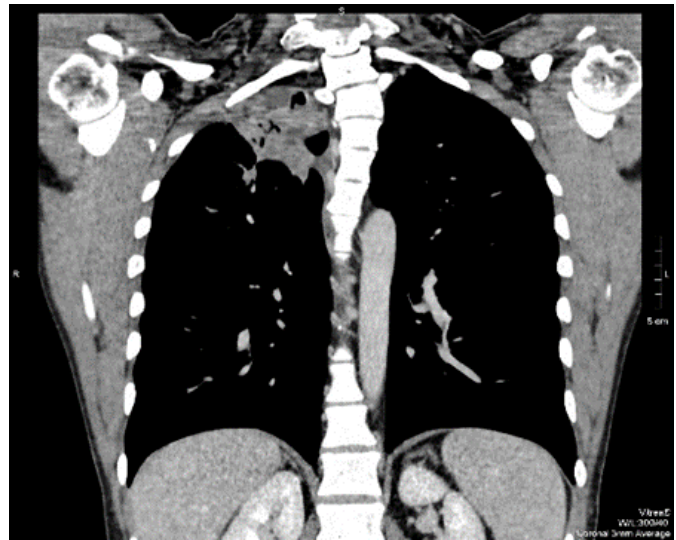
Chest multi-detector computed tomography: above lesion visible areas of necrosis (coronal section).
